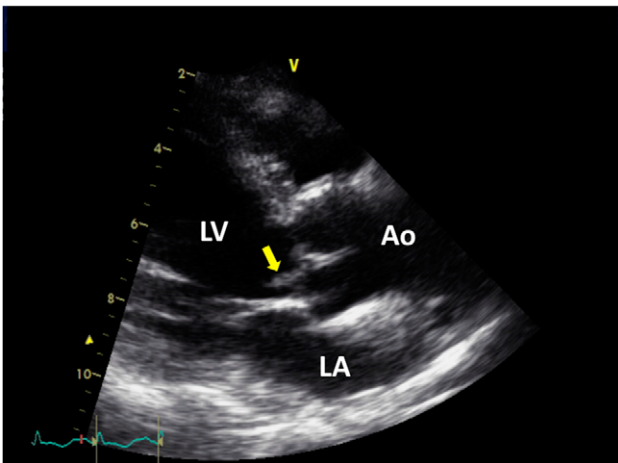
TTE at the parasternal long axis window showing a mobile echodensity attached to the ventricular surface of the aortic valve, consistent with that of a vegetation.
